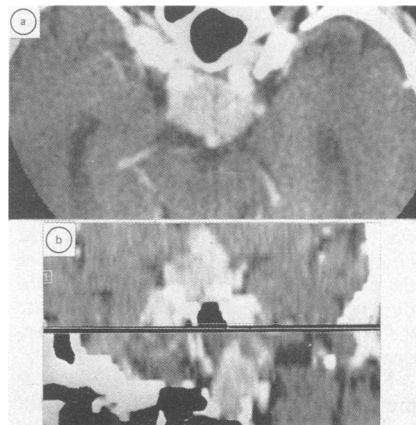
(a) A high definition CT scan in the immediate suprasellar region; (b) computerised coronal and sagittal showing a continuous intra-suprasellar lesion.
